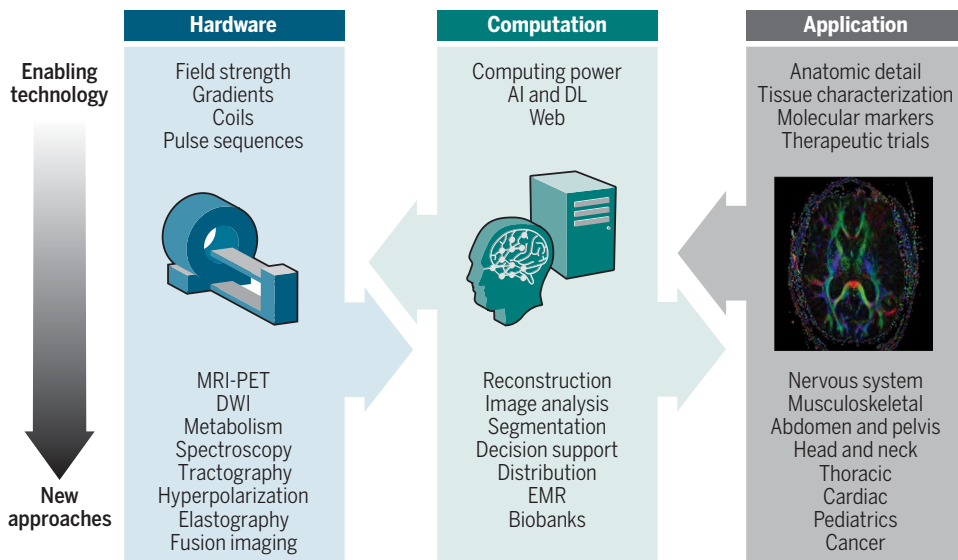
Advances in clinical MRI. Depicted are previous and projected advances in magnetic resonance imaging (MRI). Complementary developments in imaging hardware and computational analysis are facilitating improved image quality, which has enabled a broadening of MRI applicability across organ systems and will likely continue to do so in the future. DWI, diffusion-weighted imaging; EMR, electronic medical record.
